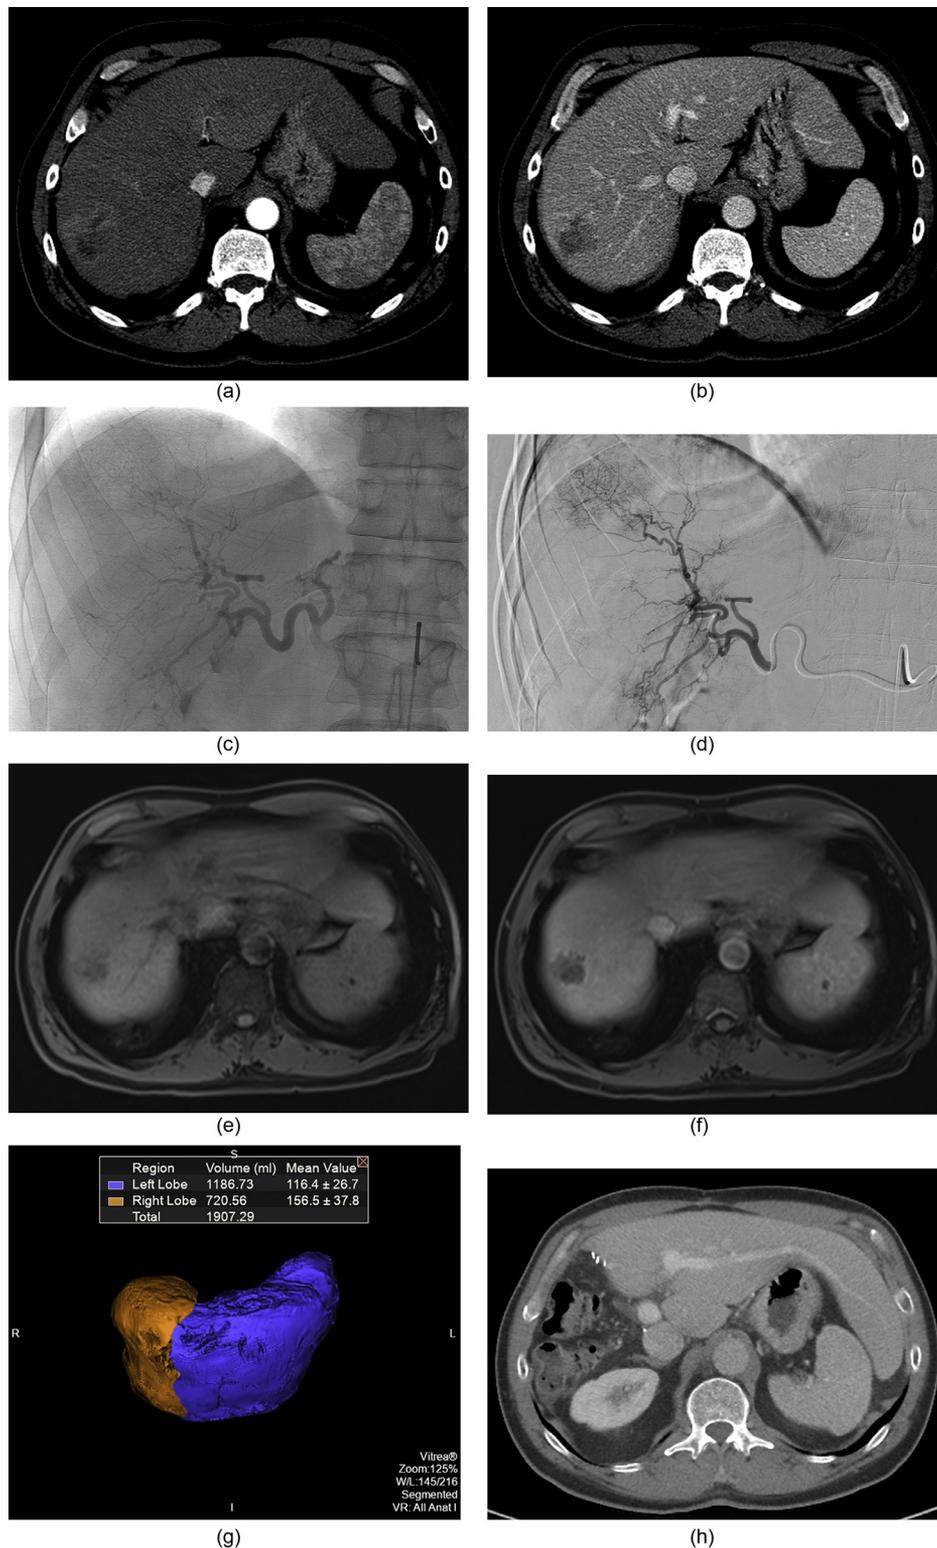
Radiation Lobectomy. Axial postcontrast images obtained in the arterial (a) and venous (b) phases demonstrate a segment 7 HCC with early arterial enhancement and portal venous washout. Right hepatic artery angiography in the early (c) and late (d) arterial phases show the right hepatic lobe arterial anatomy and hepatic dome tumor blush. Axial T1-weighted postcontrast images obtained in the arterial (e) and venous (f) phases show partial response of the segment 7 HCC with a viable tumor component noted laterally. Postprocessed volume rendering (g) of the right and left hepatic lobes shows that the FLR now represents over 60% of the patient's overall liver volume. Axial postcontrast venous (h) phase image demonstrates a hypertrophied left hepatic lobe in a patient now status post right hepatic lobectomy. The patient remains free of disease over 4 years after radiation lobectomy. FLR, future liver remnant; HCC, hepatocellular carcinoma; RE, radioembolization.
